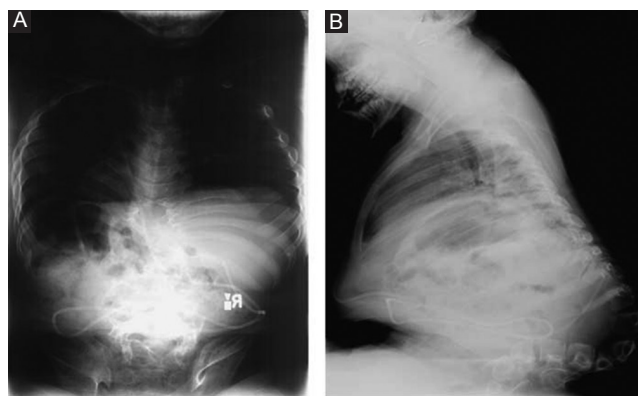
Pre-operative sitting posterior-anterior (A) and lateral (B) radiographs of the entire spine of a 9-year-old female (myelomeningocele spina bifida) with collapsing kyphosis (patient B).
